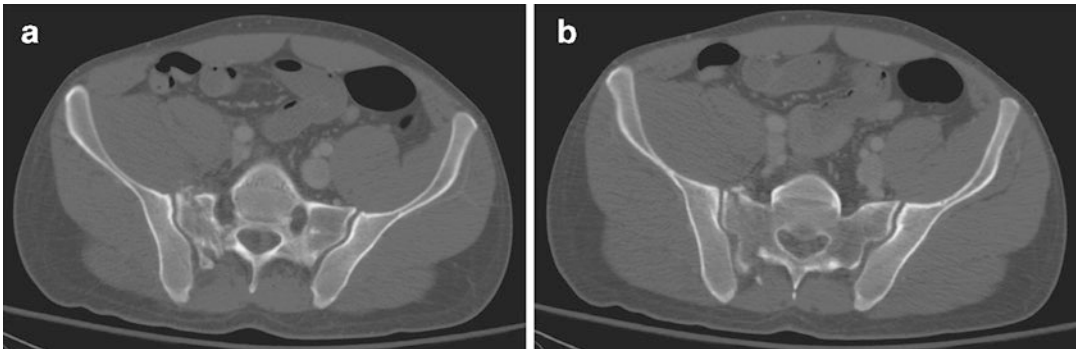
(a, b) Axial CT of the pelvis
